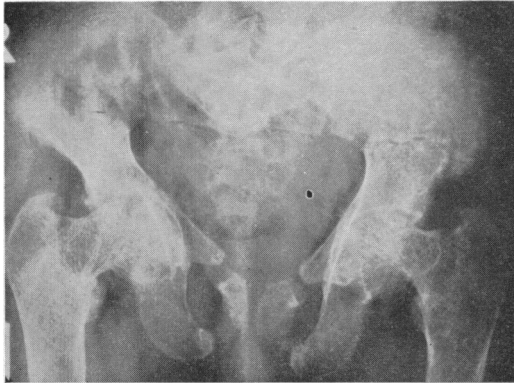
Radiograph of pelvis. Note wide symmetrical Looser's zones in pubic and ischiopubic rami, and narrow zones running from angle of brim of pelvis.
